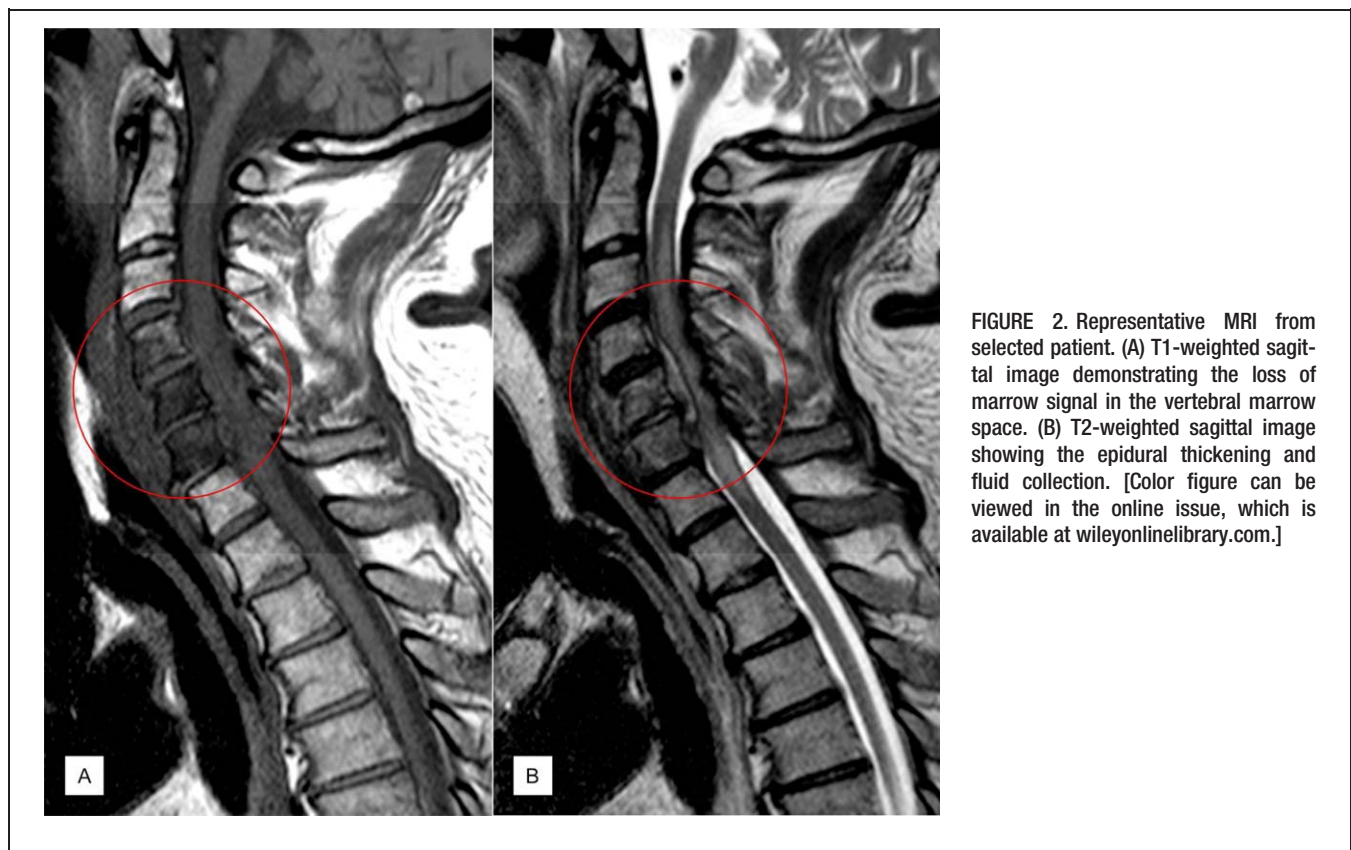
Representative MRI from selected patient. (A) T1-weighted sagittal image demonstrating the loss of marrow signal in the vertebral marrow space. (B) T2-weighted sagittal image showing the epidural thickening and fluid collection. [Color figure can be viewed in the online issue, which is available at [wileyonlinelibrary.com](http://wileyonlinelibrary.com).]
